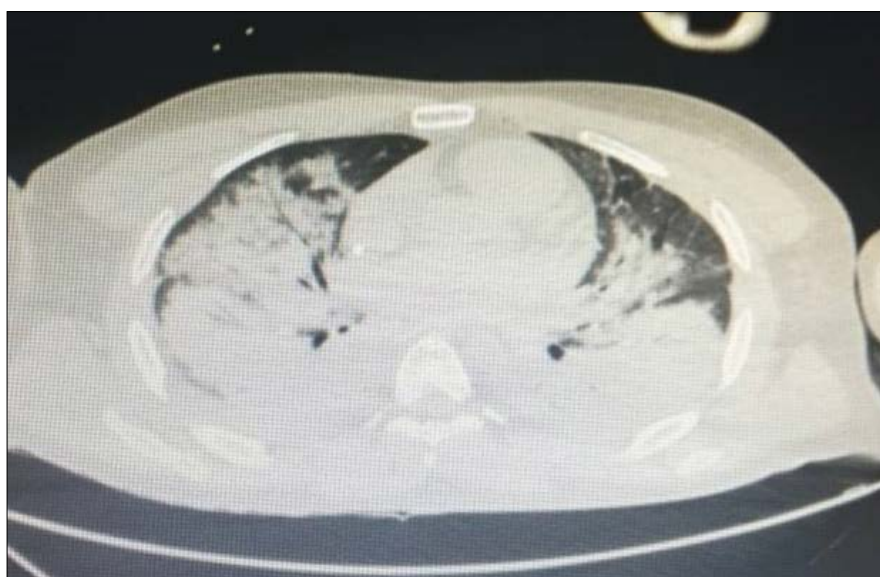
HRCT Chest: Diffuse heterogeneous opacities involving both lung suggestive of consolidation/pulmonary edema
